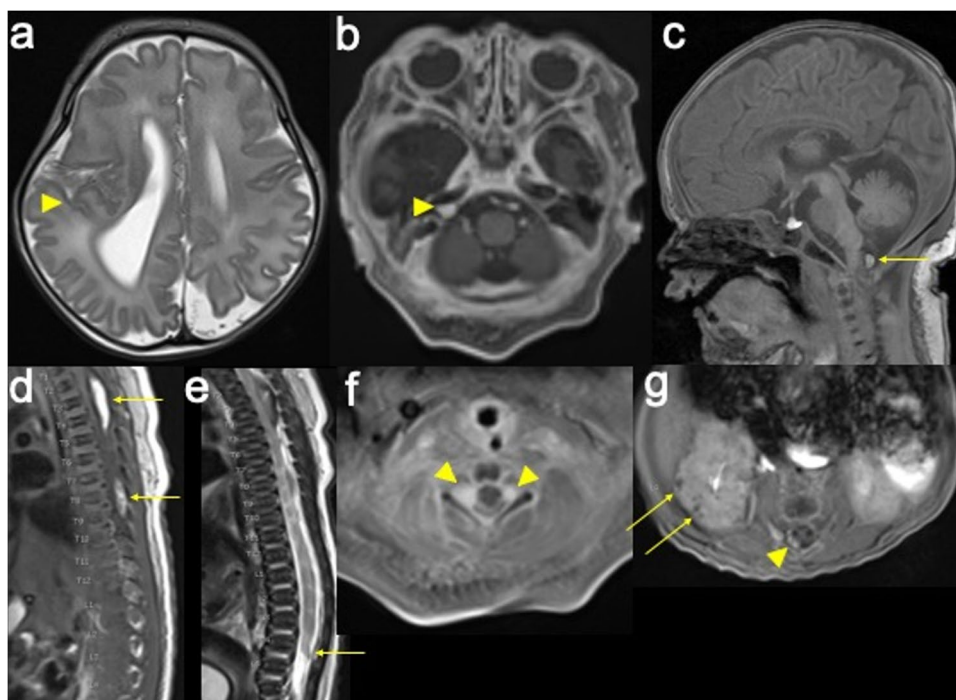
2 day old girl with congenital verrucous epidermal naevus syndrome, seizures and cranial ultrasound suggesting right hemimegalencephaly and right temporal lobe polymicrogyria. a Axial T2-weighted imaging of the brain demonstrates asymmetric enlargement of the right cerebral hemisphere and right lateral ventricle and suspected polymicrogyria involving the right posterior perisylvian cortex (arrowhead). b Axial T1-weighted, fat-saturated, post-contrast imaging of the brain demonstrates an enhancing mass in the right IAM (arrowhead). c Midline sagittal T1-weighted imaging of the brain demonstrates a lipomatous lesion at the dorsal cervicomedullary junction (arrow). d Sagittal T1-weighted imaging of the spine demonstrates further intradural, extramedullary lipomatous lesions
